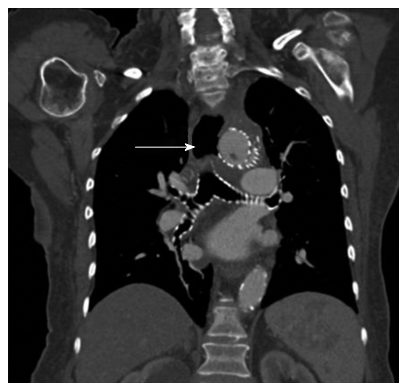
Computed tomography demonstrating an aorto-esophageal fistula (arrow).
